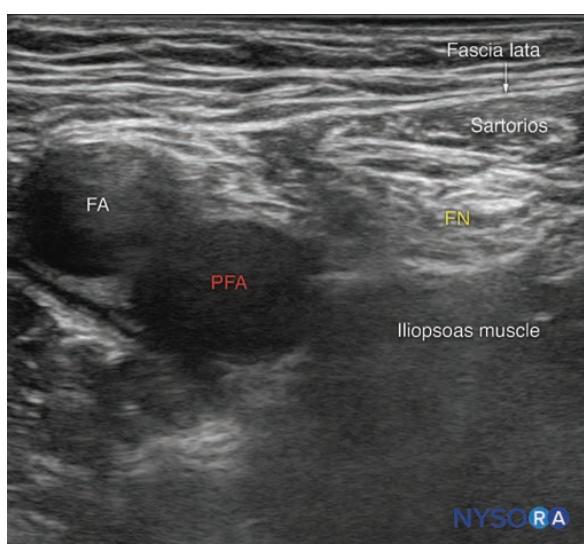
Bifurcation of the femoral artery (FA) into the profunda femoris artery (PFA). For a complete femoral nerve (FN) block, the injection is made proximal to the bifurcation where only a single artery is seen in the ultrasound.
